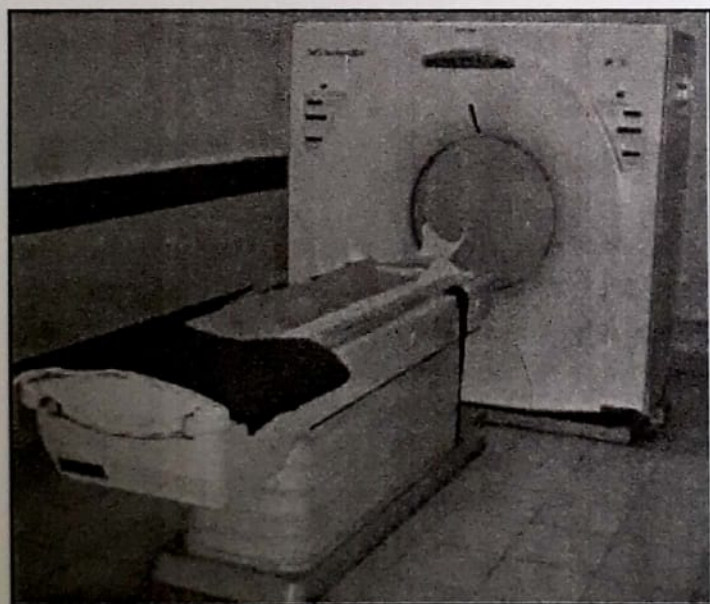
X vision GX machine on which the spiral 3D computed tomographic images were taken.
